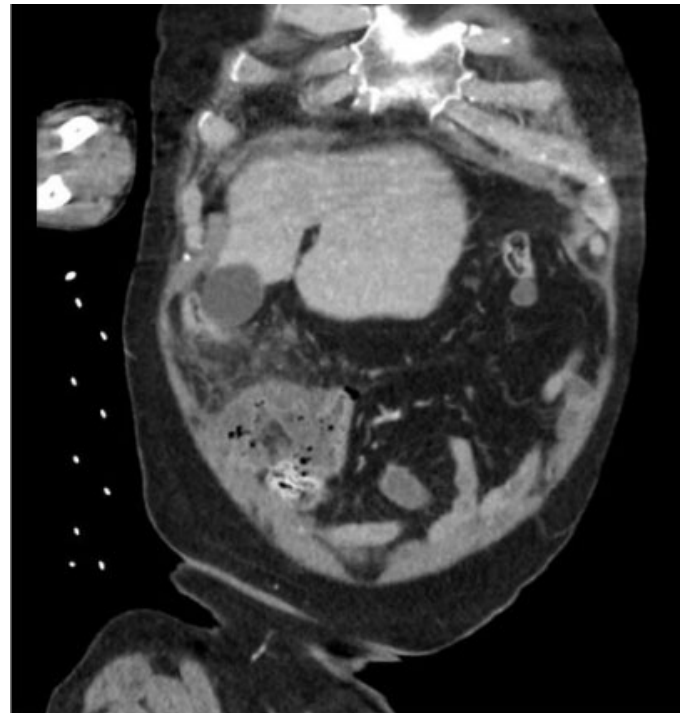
Coronal CT image demonstrating extraluminal gas locules adjacent to the cecal pathology.
